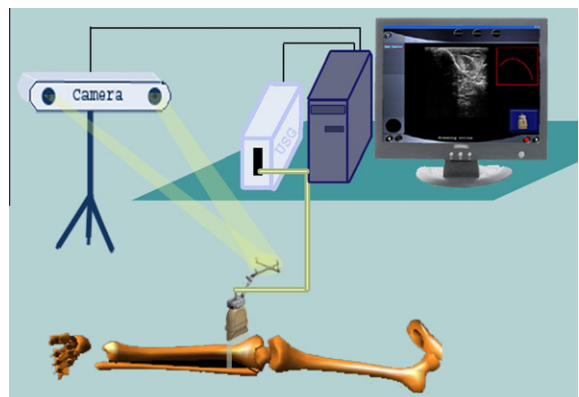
A scheme of 3D sonography to investigate bone geometry.
